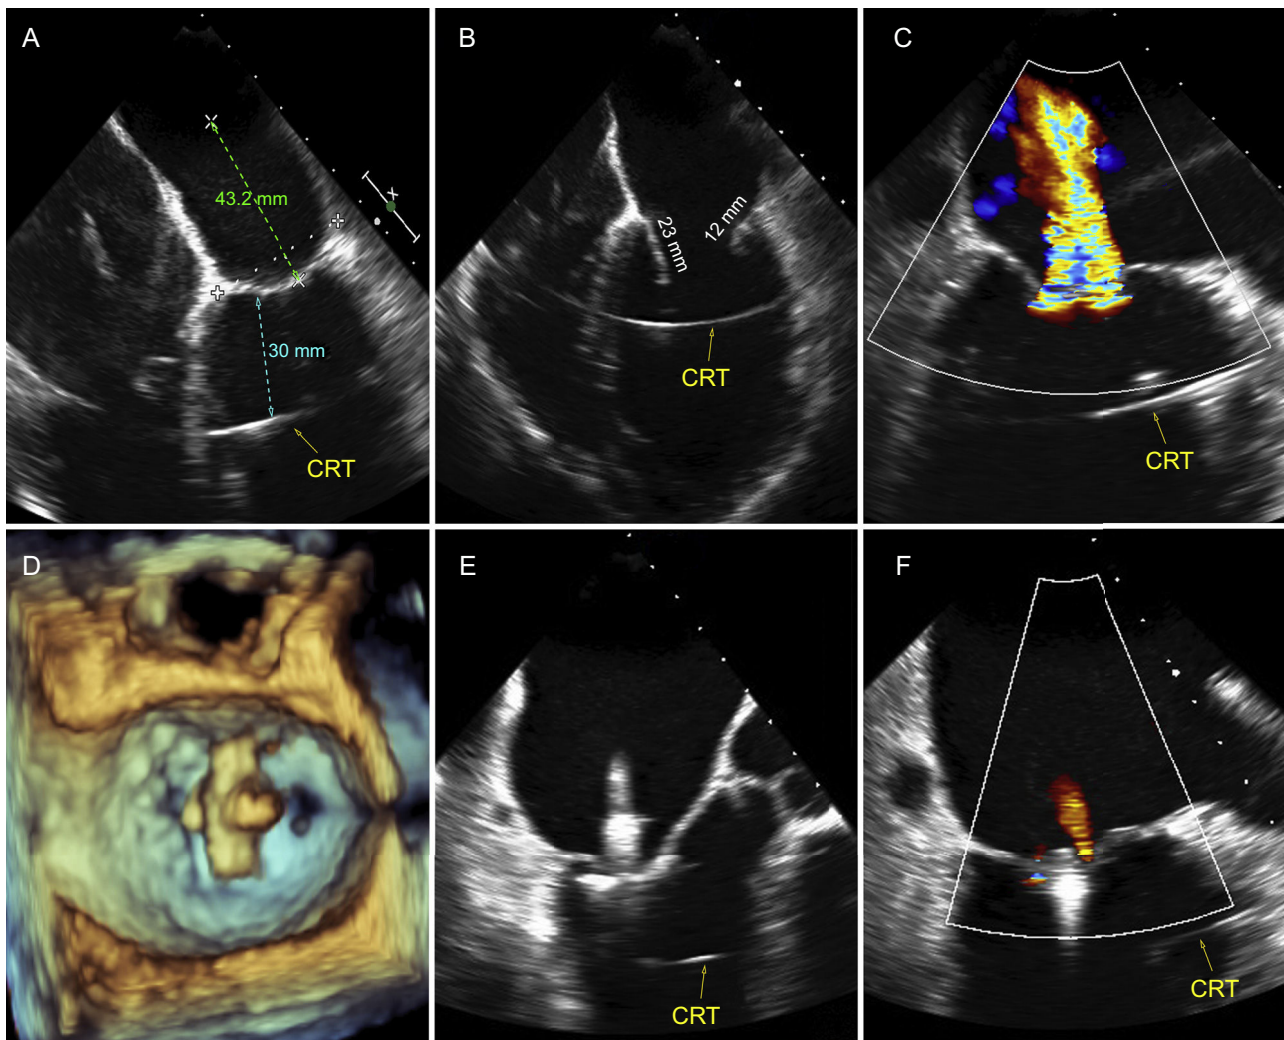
Transesophageal echocardiography images during the intervention. A and B, 4-chamber view (0°); relationship of the closed and open mitral valve and with the CRT lead. Panel A shows the distance from the point of transeptal puncture to the line of fusion of closure of the mitral leaflets and the distance from the lead to the mitral plane. Panel B shows the measurements of the A2/P2 leaflets, respectively. C, bicommissural view (70°); severe mitral regurgitation toward the left atrium can be observed. D, 3-dimensional image of the MitraClip, perpendicular to A2/p2 leaflets of the mitral valve. E, outflow tract view (120°). F, bicommissural view (70°); capture of the mitral leaflets (E) and release of the clip (F), with minimal residual regurgitation, and its position relative to the CRT lead. CRT, cardiac resynchronization therapy.
